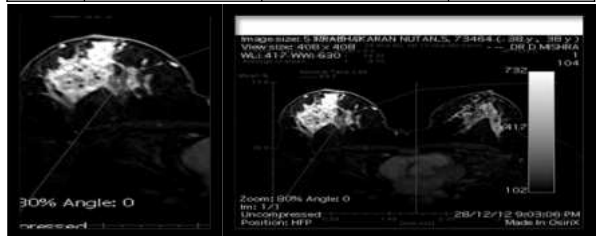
Large, irregular mass with heterogenous enhancement with rapid uptake and plateau phase, categorized as MRI BIRADS 5 lexicon
